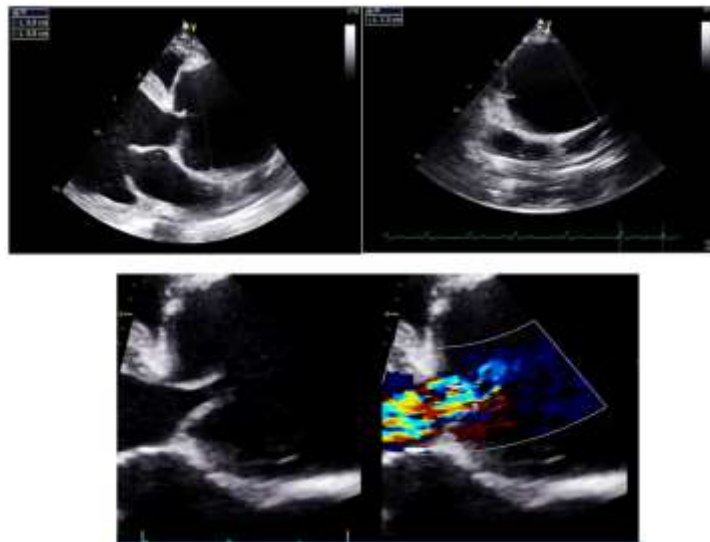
(TTE)parasternal long-axis view showing ectasia of the initial part of the aorta with severe aortic insufficiency
